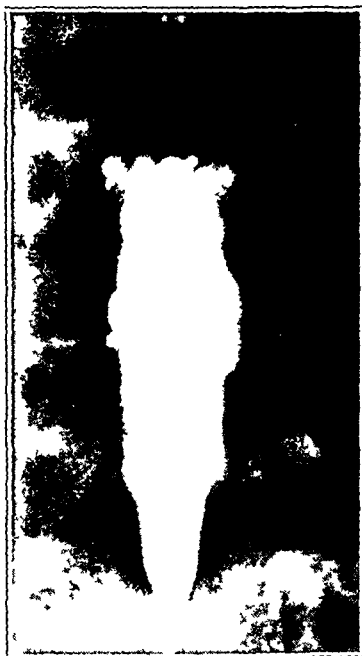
Anteroposterior roentgenogram showing a normal configuration of the caudal sac as outlined by radiopaque oil in a patient in whom a protruded fifth lumbar disk was found and removed
